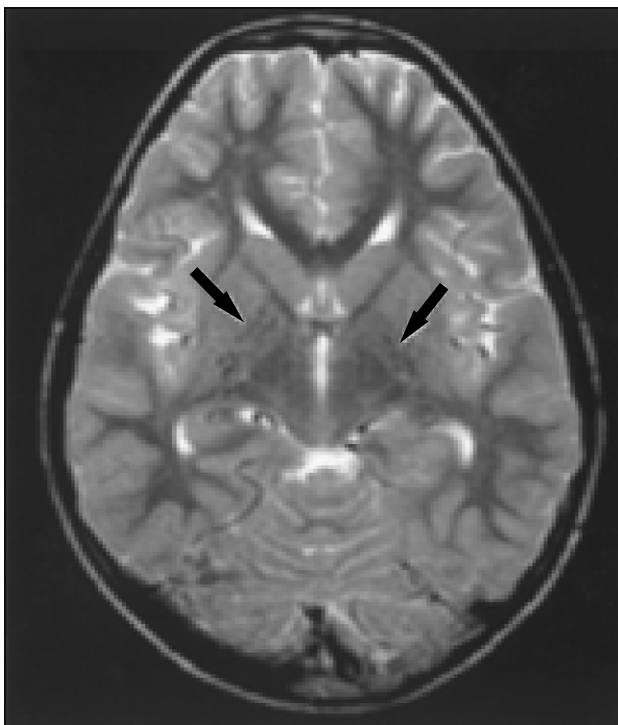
T2 weighted MRI showing multiple flow voids (arrows) within the basal ganglia and bilateral frontal areas of cortical infarction and atrophy.
